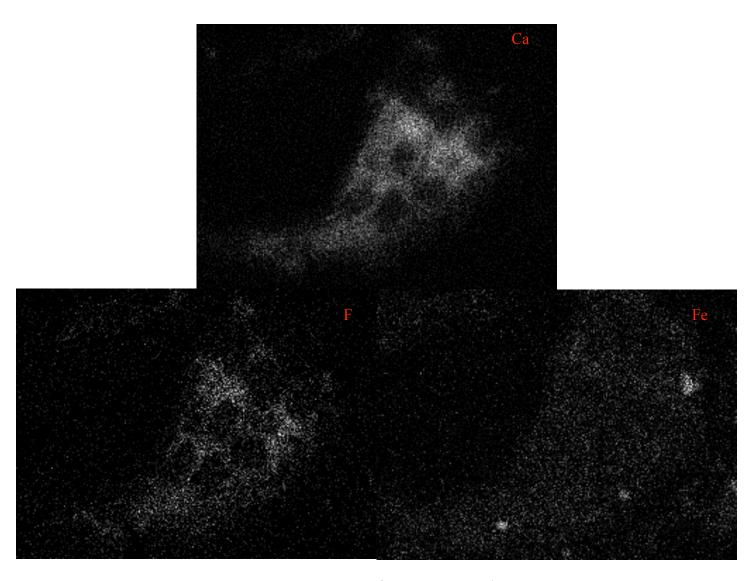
X-ray maps of TIND 1-4 Ca, F and Fe
